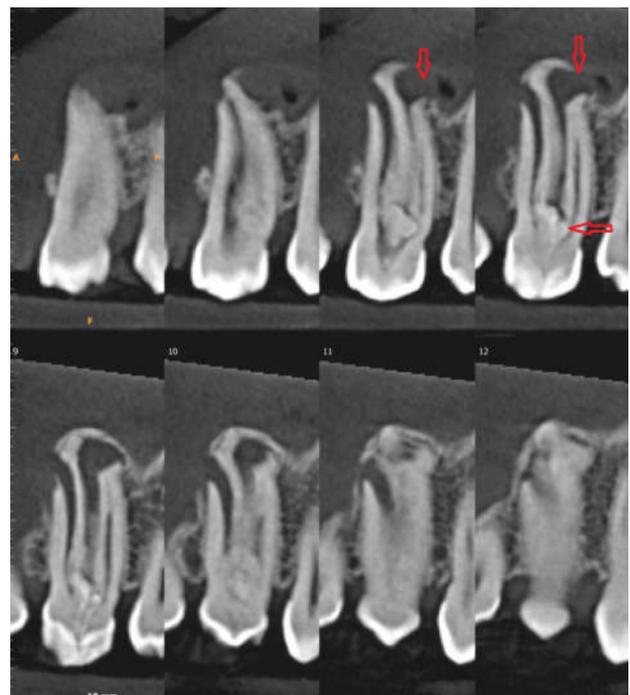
Coronal cross sections showing extent of invagination and periapical radiolucency
